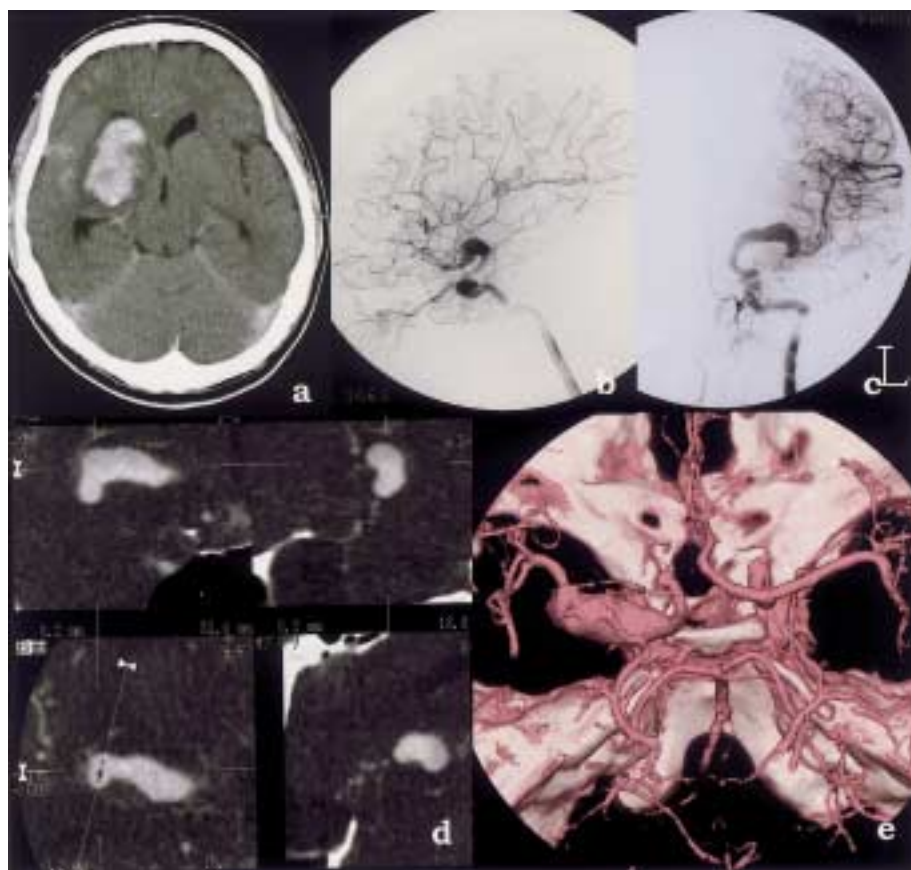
a CT scan, done at 2nd bleeding, shows left basal ganglion hematoma and SAH.
